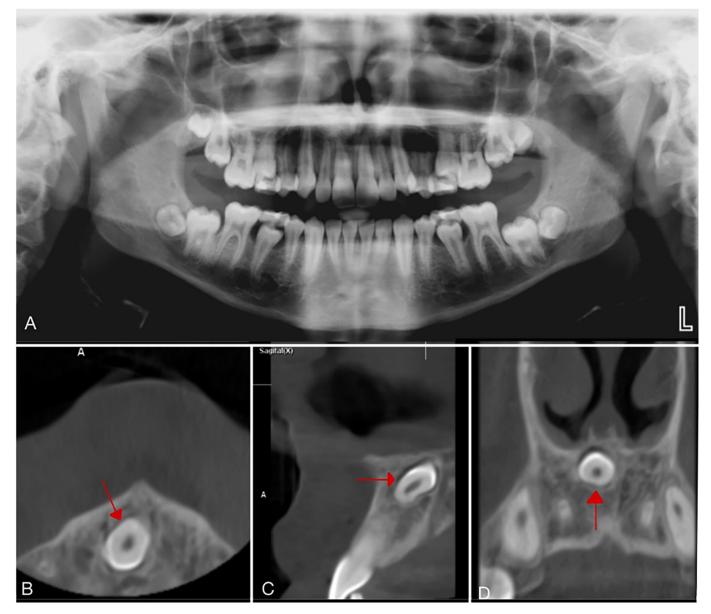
Radiographs of a sample case showing mesiodens without complications in permanent teeth. (A) Panoramic radiographic image. Mesiodens could not be observed clearly due to superposition of the hard palate. (B) Axial CBCT image. Mesiodens was observed in the midline inverted position. (C) Sagittal CBCT image. (D) Coronal CBCT image (red arrows pointed to mesiodens).
